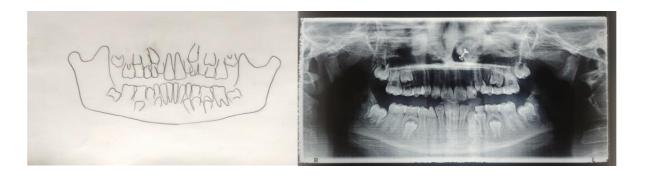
Orthopantomaogram showing Eruption of Teeth
